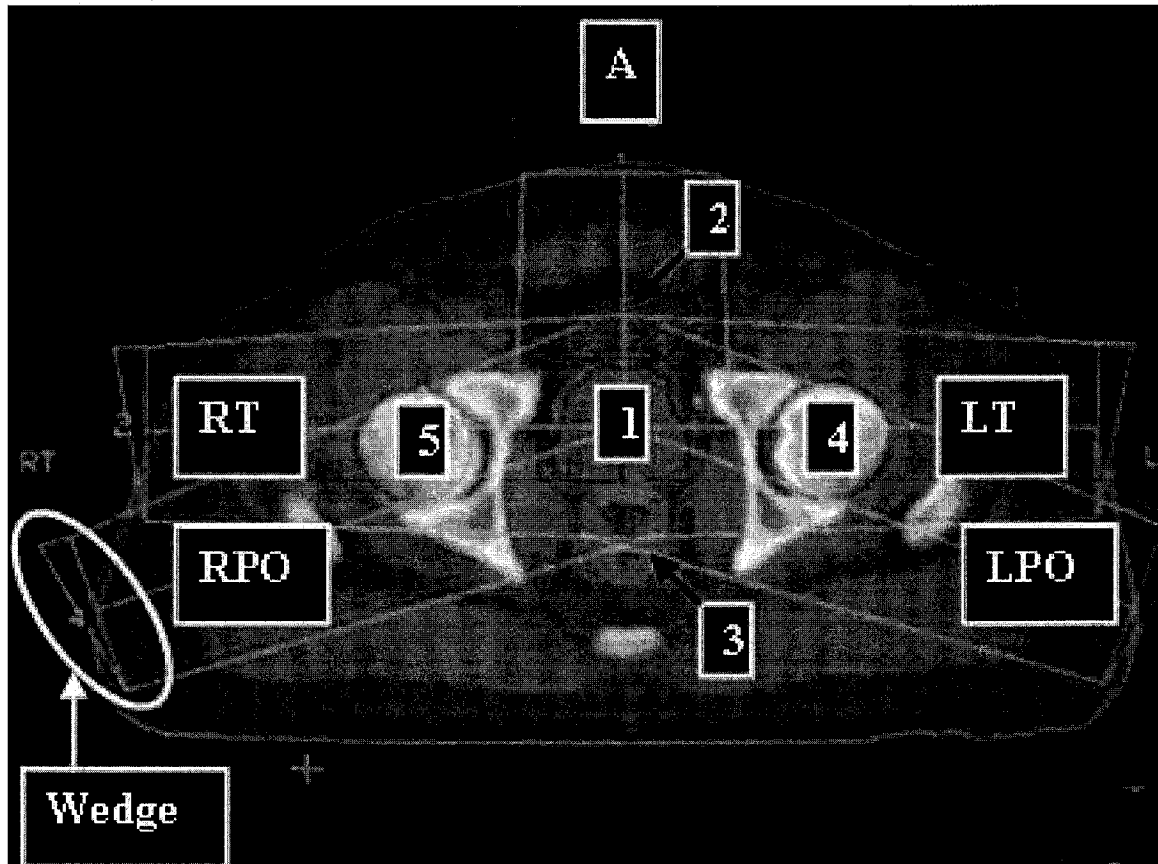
Axial CT image and 3D-CRT photon beam arrangement for typical prostate patient treated by EBRT at the MGH The contours indicated are: (1) the prostate, (2) the bladder, (3) the rectum, (4) the left femoral head and (5) the right femoral head.
